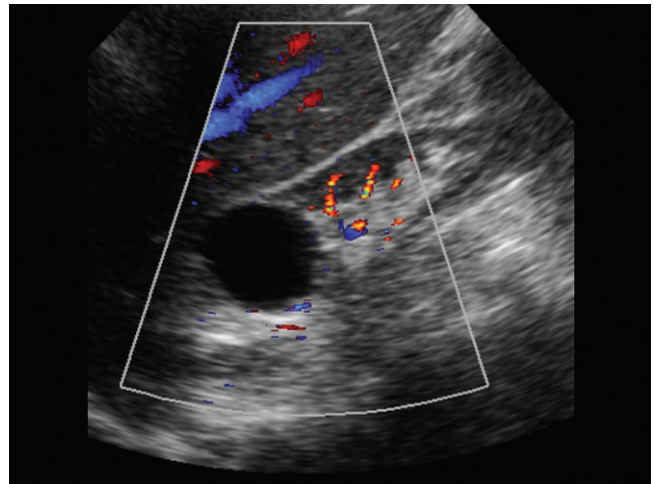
Color Doppler evaluation does not demonstrate internal vascularity.
